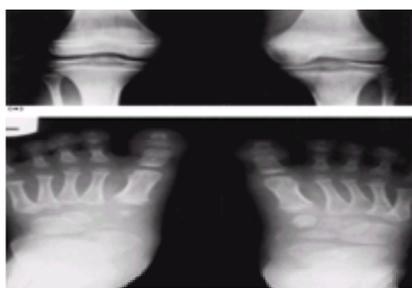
(a) Radiograph of knees to show overgrowth of the medial epicondyle of the femur due to persistent arthritis of that knee. (b) Radiography of feet to show
